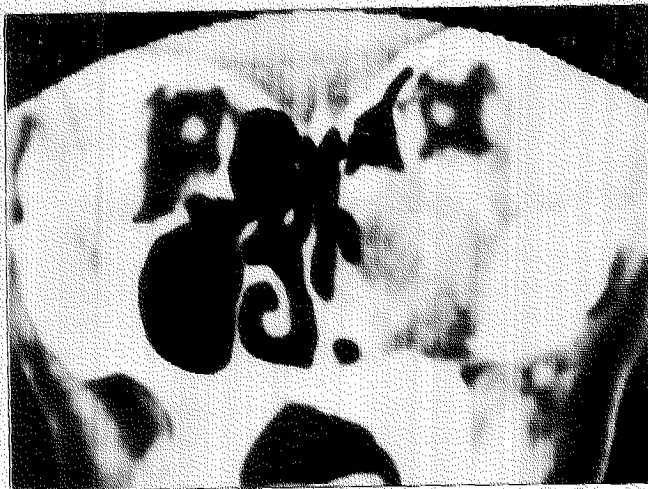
SINUS CT (PRETREATMENT)
